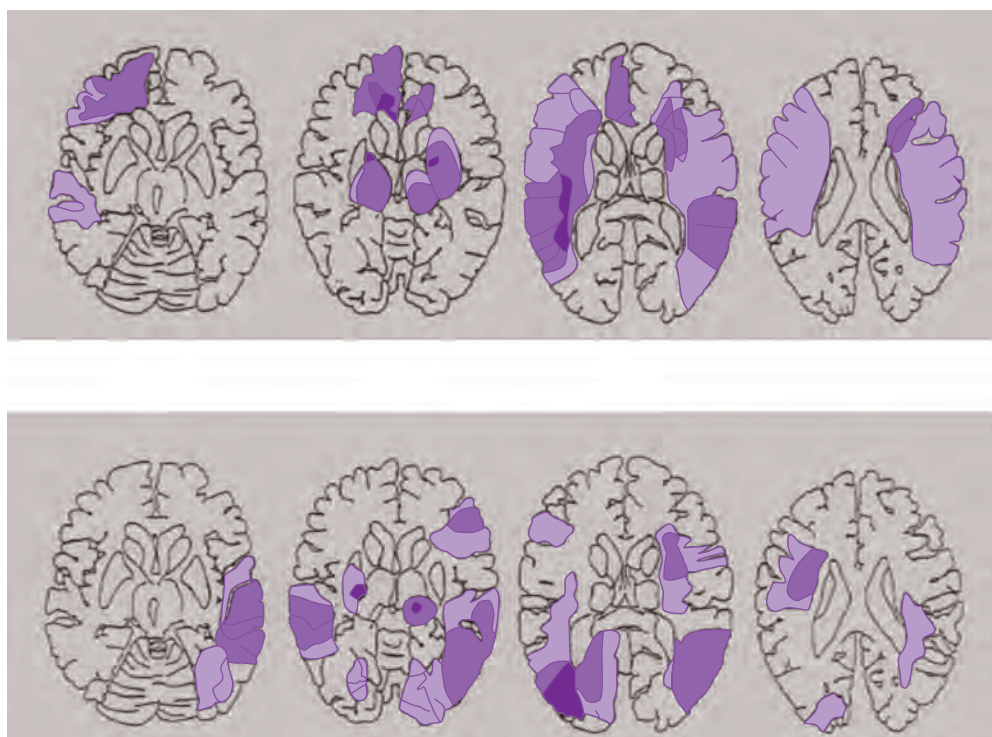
Lesions on brain CT or MRI with micturitional disturbance (upper panel) and without (lower panel) (Sakakibara *et al.* 1996).
